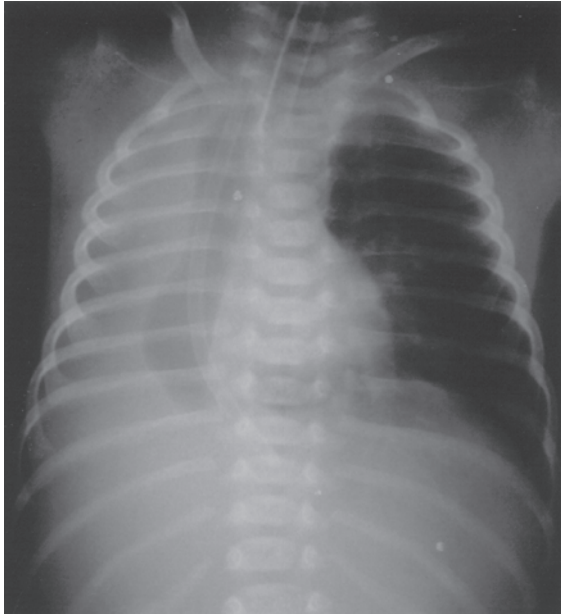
Posterior-anterior chest X-ray shows opaque right hemithorax. Note the left lung hyperinflation and slight cardiac displacement.
